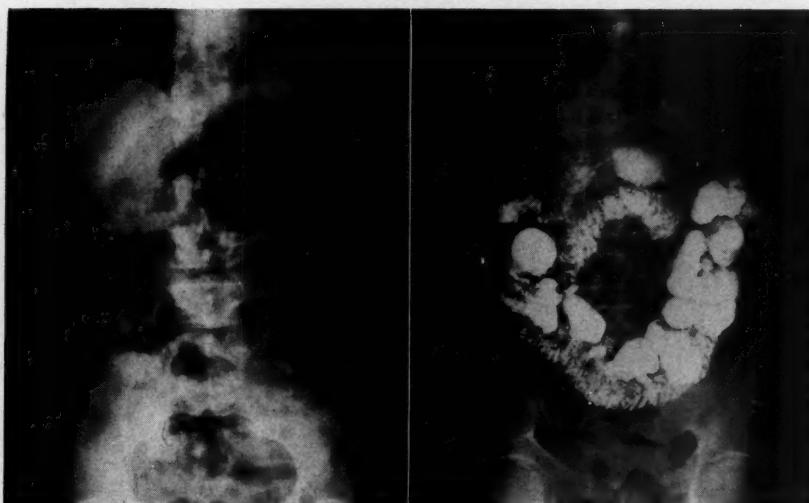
(left). Scout roentgenogram of the abdomen in the erect position in case 1.
